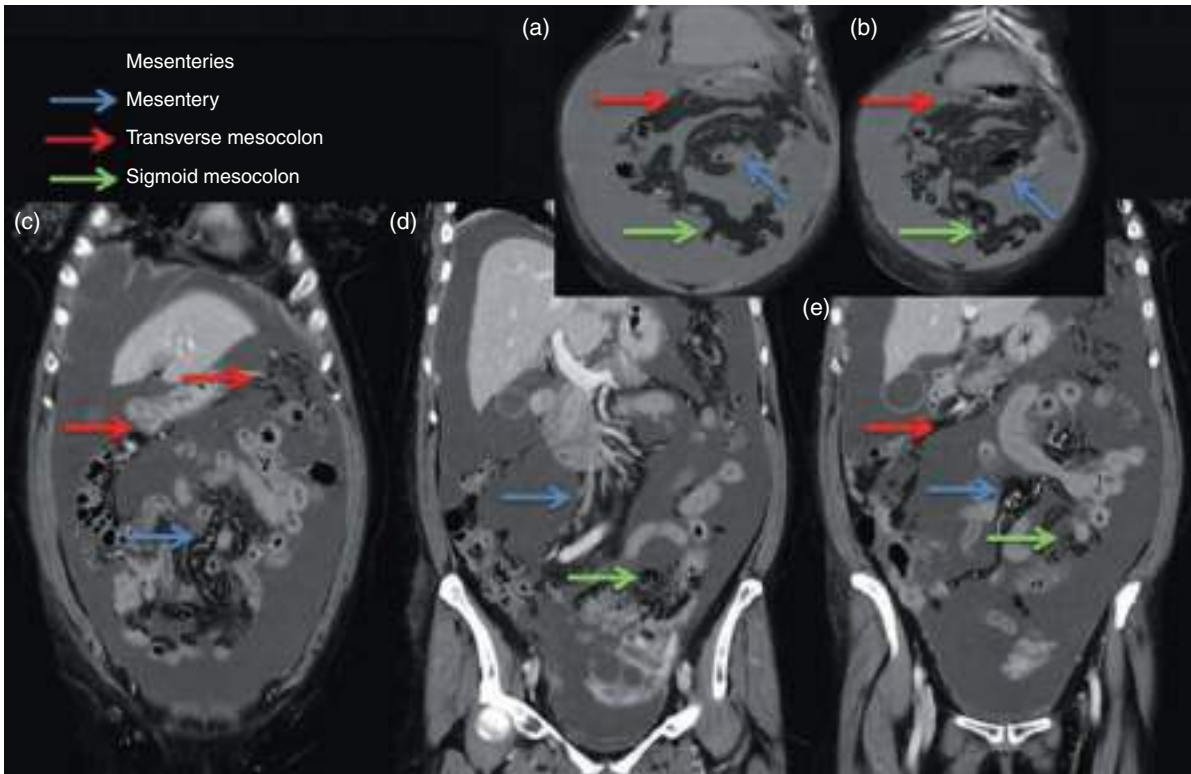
Mesenteries in patient with ascites due to peritoneal carcinomatosis secondary to ovarian tumor. (a–e) Coronal contrast-enhanced MPR CT image (portal venous phase).
